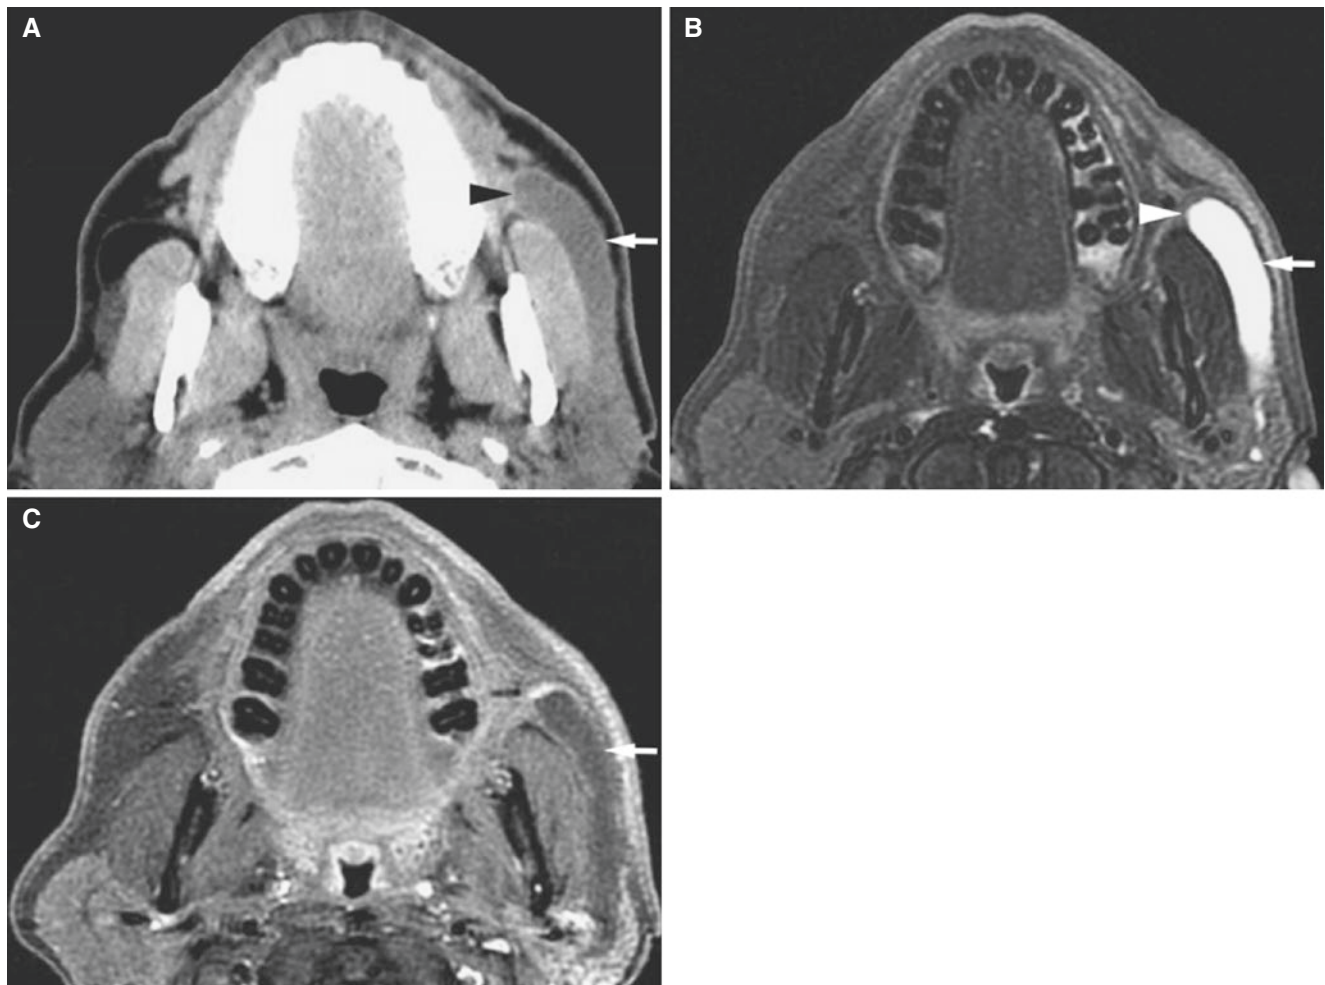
Stenosis and dilatation of Stensen's duct but no stones; 56-year-old male with a remote history of injury to the left cheek after which he developed intermittent swelling (gland itself was not enlarged or abnormal on CT or MRI imaging). On clinical examination there was scarring at the orifice of the left Stensen's duct. (A) Axial post-contrast
